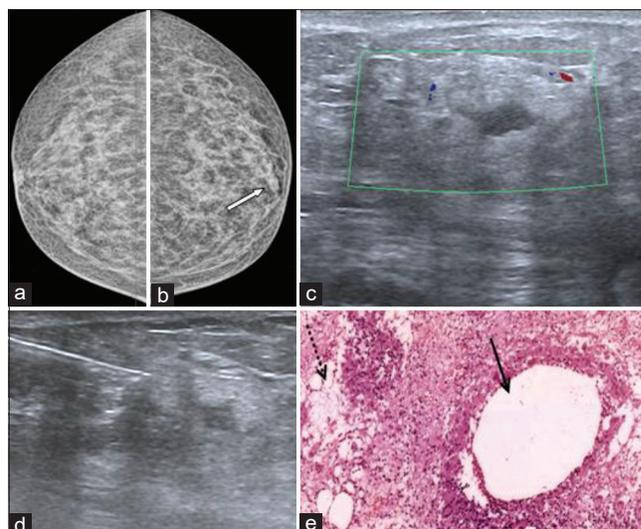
A 65-year-old female with a history of pain in the left retro areolar region breast with no other specific history X-ray mammogram CC view (a) Right breast with no abnormality (b) Left breast shows a subcentimeter irregular high-density nodularity in the subareolar region (arrow) (c) Ultrasound with color Doppler shows an irregular parallelly oriented circumscribed hyperechoic mass with central cystic changes with combined posterior features and absent vascularity. (d) Ultrasound-guided tru-cut biopsy of the mass (e) H & E: Chronic Mastitis with focal cystic change (Black Arrow) and adjacent fat necrosis (Dotted Arrow) x100
